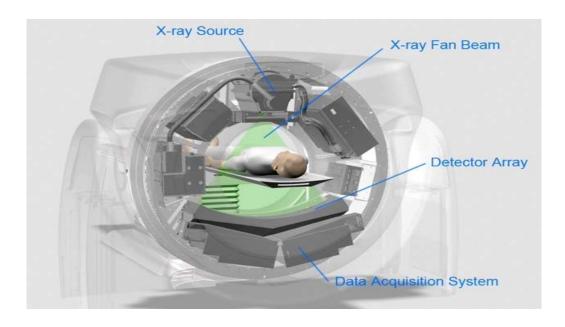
shows the x-ray tube and the detector array are oppositely placed, inside the gantry. Adopted (Thorsten, 1965)
